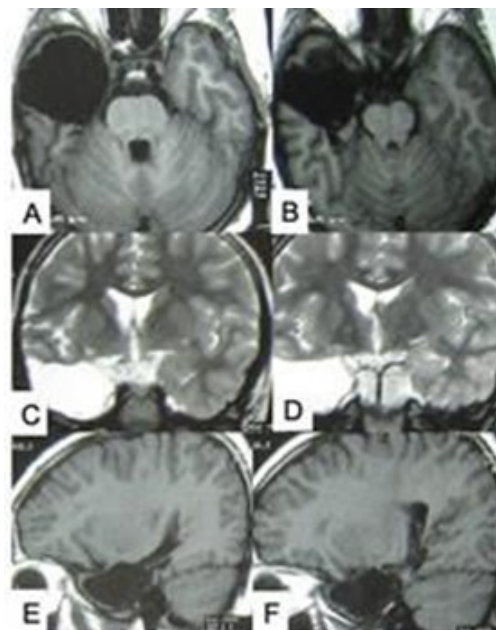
MRI of brain; (A,B) T1W axial, (C,D) T2W coronal and (E,F) T1W sagittal postoperative images after right amygdalohippocampectomy plus standard anterior temporal lobectomy in a case of MTS. Source: Figure by authors.
